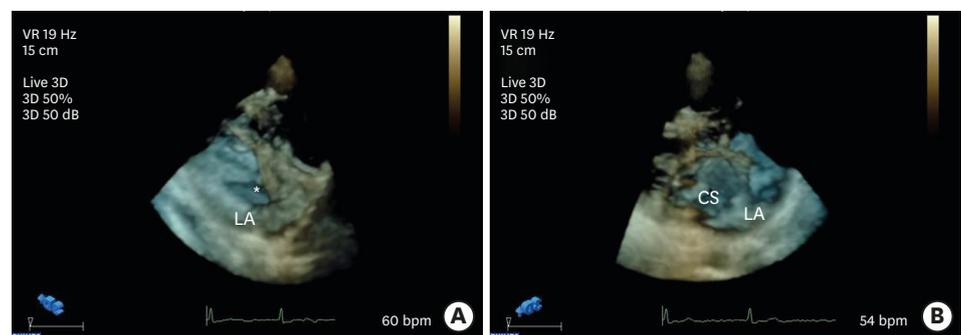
Three-dimensional echocardiography. (A) In the en face view of the LA, an ovoid-shaped defect (asterisk) was found between the CS and the LA, posterior to the mitral valve. (B) After horizontal rotation of the image, the bottom of the CS and the blinded pouch were visible through the defect. No communication between the CS and the right atrium was visible, which suggested CS orifice atresia. CS: coronary sinus, LA: left atrium.
